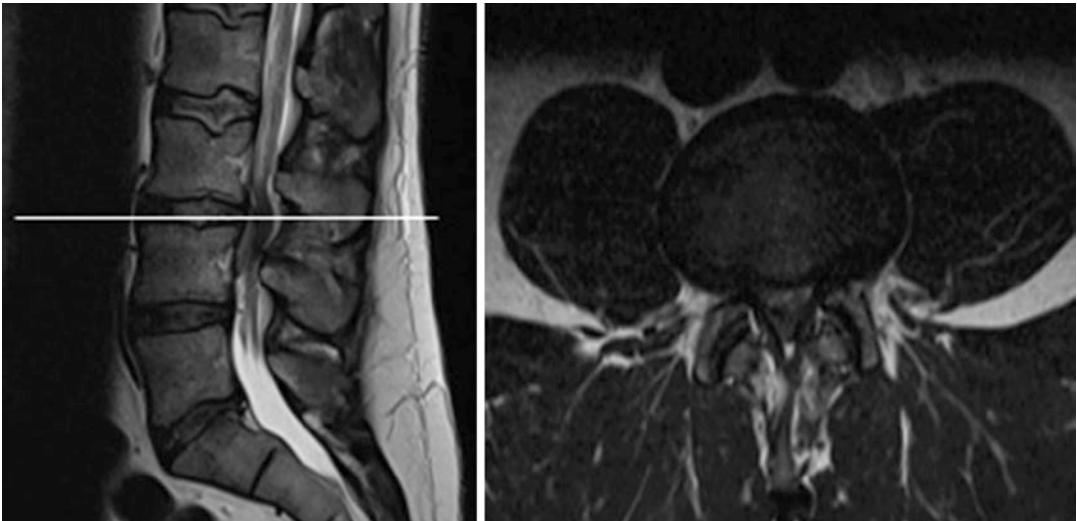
Sagittal (left) and axial (right) MRI showing a large, median and downward migrated disc fragment at L3-L4 level, with cauda equina compression
